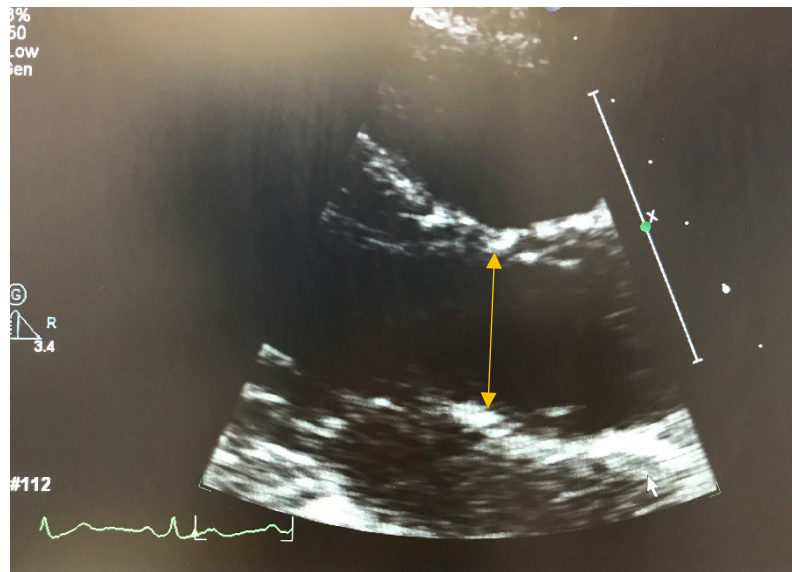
Parasternal long axis view of the left ventricular outflow tract diameter
